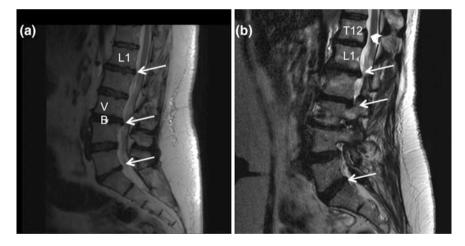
Degenerative disk disease by magnetic resonance imaging. Sagittal view of a lumbar spine, T2 weighted images. a Disk bulging at multiple levels, most prominent at L1–L2, L3–L4 and L5–S1, and indenting the spinal canal (*arrows*). VB indicates vertebral body; *Asterisk* indicates intervertebral disk. b Disk herniation at the T12–L1 level, with migration of disk material posterior to the T12 vertebral body (*arrowhead*). Disk bulging (*arrow*) is present at L1–L2 and L2–L3 as well
